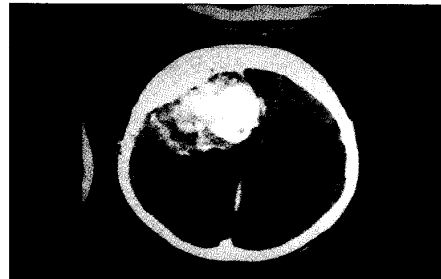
CT scan of brain shows right frontal meningioma
